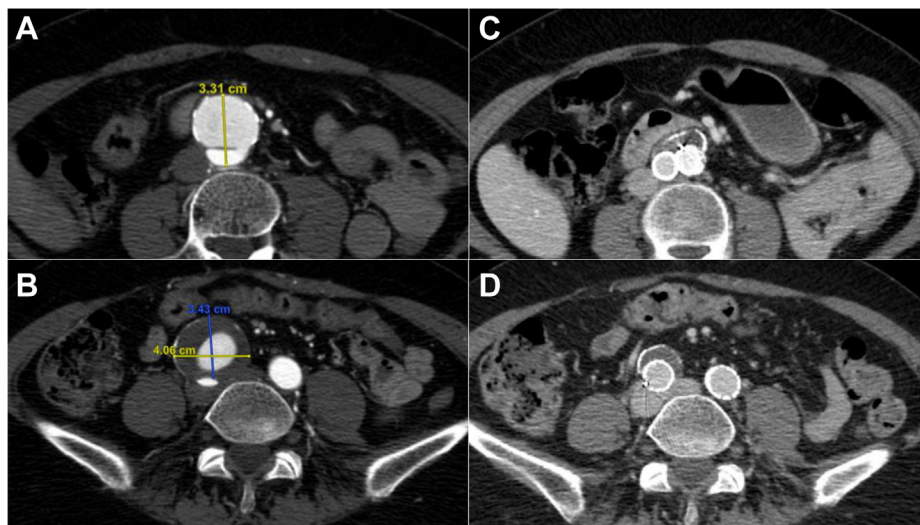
Axial views of computed tomography angiogram of a 59-year-old woman with vascular Ehlers-Danlos syndrome (VEDS; *COL3A1*, c.555delT, p.Gly186ValfsTer36, null variant) showing a 33-mm infrarenal abdominal aorta with dissection (A) and a 41-mm right common iliac artery aneurysm (B). Axial views of computed tomography angiogram 4 years later, showing the infrarenal abdominal aorta (C) and common iliac arteries (CIAs; D) with favorable remodeling.
